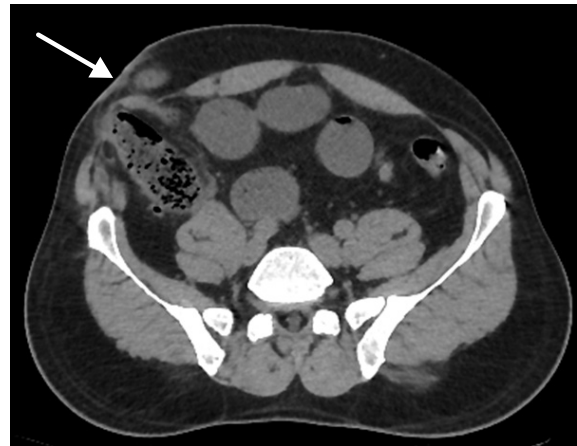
Computed tomographic image showing beak sign
